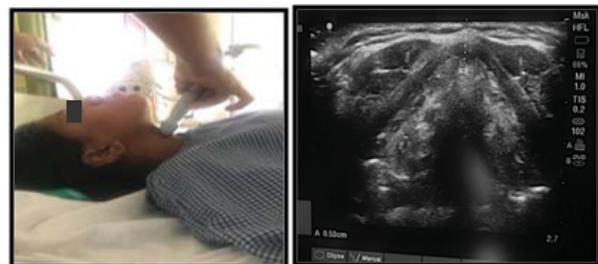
Probe placement and ultrasound image.
